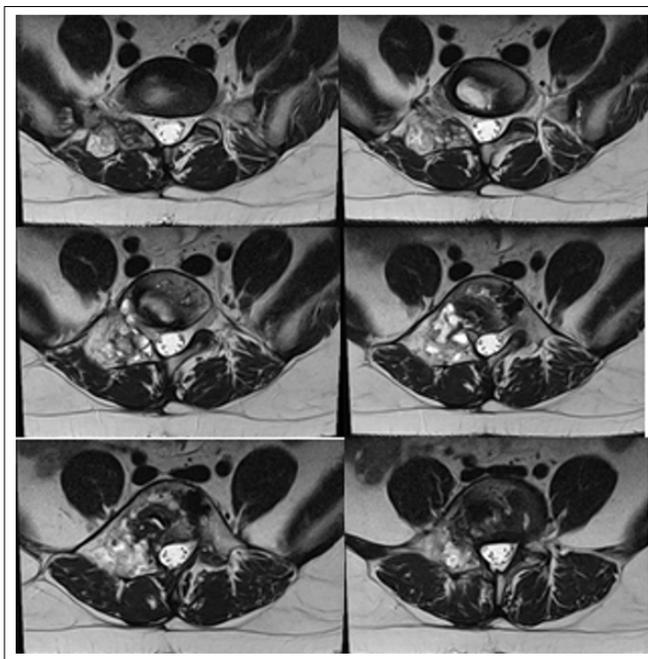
Spine MRI after 1 Year from IMRT
